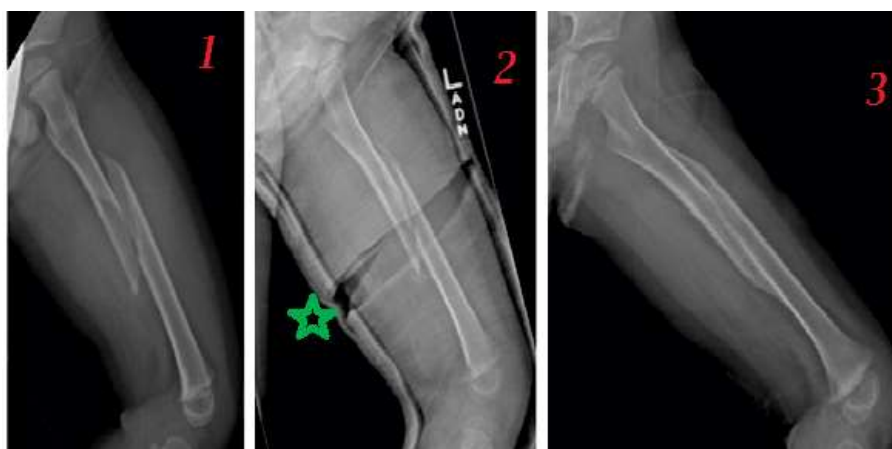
Radiographs demonstrating a femoral shaft fracture at injury (panel 1), one week after initial casting (panel 2), and two months after casting with complete healing (panel 3). The green star and lines in panel 2 denote the area where the cast was wedged to better align the bone.
